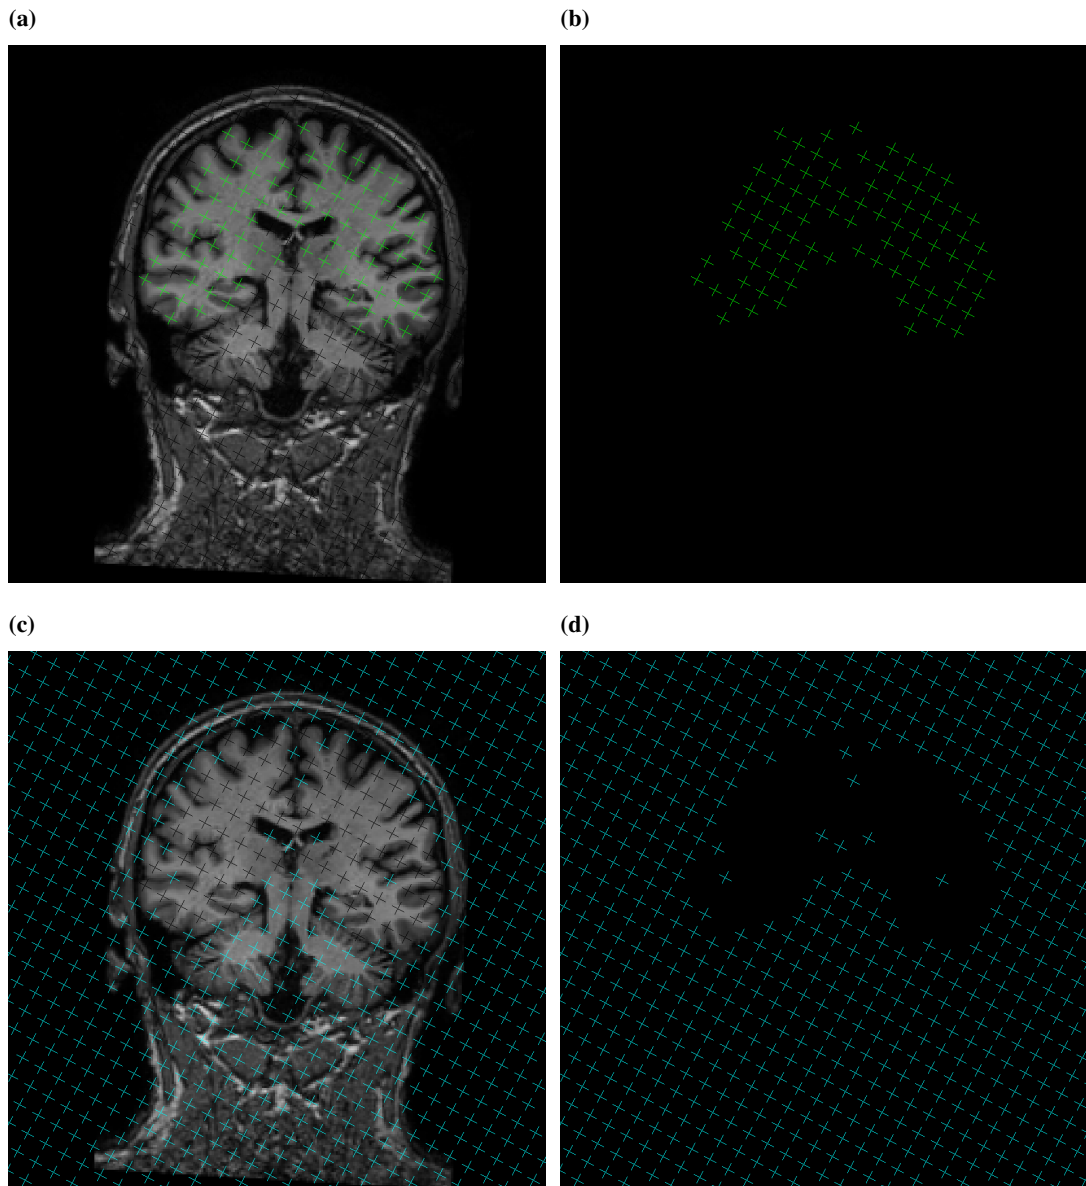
The 8th slice of a brain MR image in the coronal view processed by EASYMEASURE with (a) the counted test points (green) covering the cerebral parenchymal tissue are overlapped on a ‘nu.mgz’ brain profile; (b) the same counted grid (green) is extracted from (a) without brain profile background; (c) the uncounted grid (cyan) both outside the cerebral boundary and covering the ventricles is overlapped on a ‘nu.mgz’ brain profile; (d) the uncounted grid (cyan) is extracted from (c) without brain profile background.
